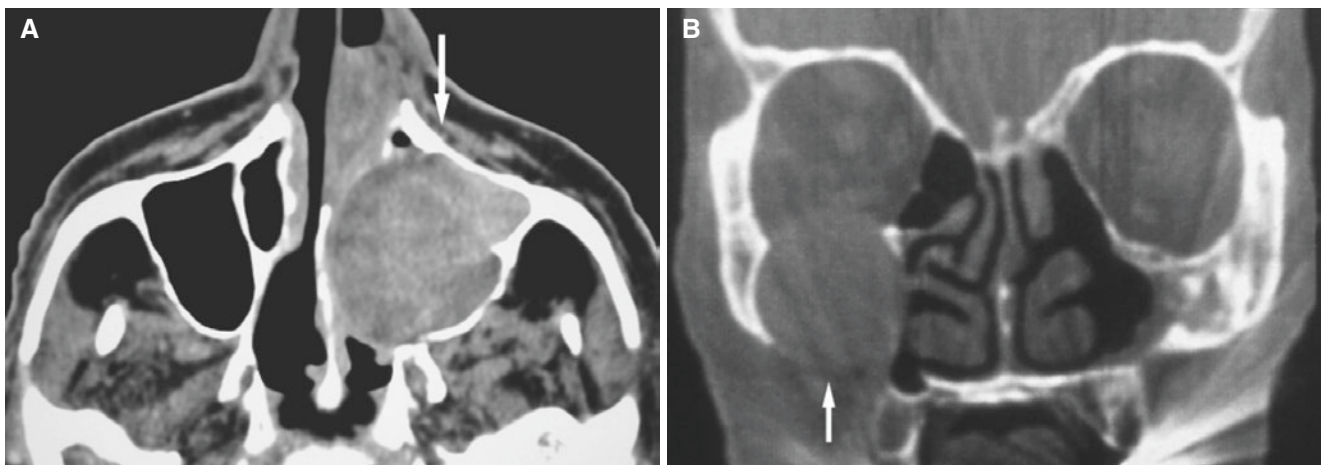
Maxillary sinus mucocoele; two patients with long history of chronic sinusitis and sinus surgery. (A) Axial CT image shows expansive process in the entire left maxillary sinus (*arrow*) extending to
